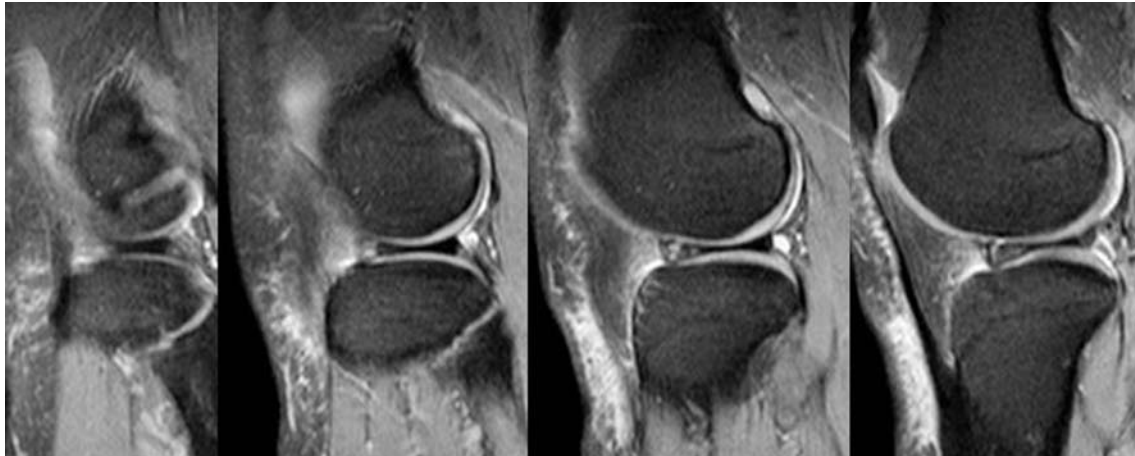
Sequential sagittal fat-suppressed T2-W MR images taken through the lateral compartment of the left knee of a 42-year-old woman show four body segments of the lateral meniscus, indicating the presence of a discoid meniscus. High signal intensity in the anterior horn is suggestive of internal mucoid degeneration. Also note the post-traumatic infrapatellar subcutaneous oedema.
